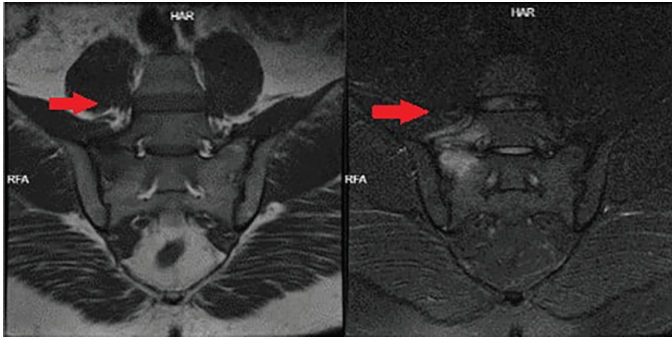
MRI examination revealed a hyperintense change in the T2A sequence and a hypointense large intensity change in the T1A sequence in the right wing of the sacrum at the right sacroiliac level
